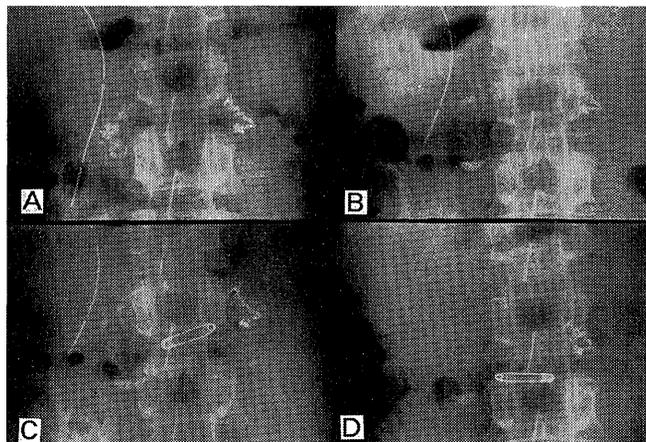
Plain abdominal X-rays in case 1
